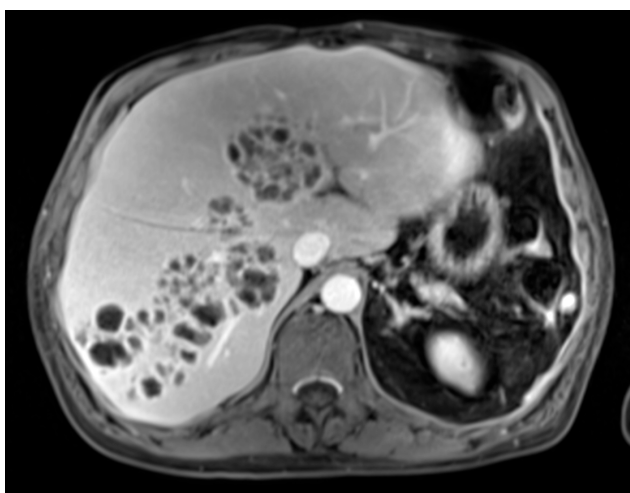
Transverse section of magnetic resonance imaging
